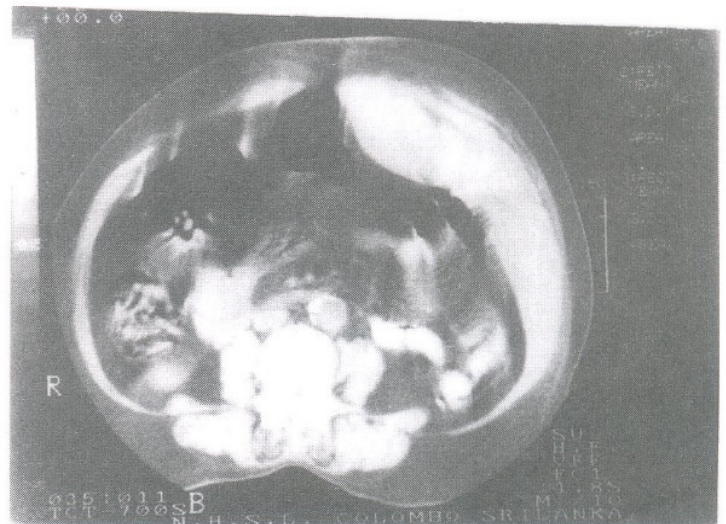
CT scan of abdomen showing a large haematoma in the left rectus abdominis muscle. There is no free fluid in the peritoneal cavity.
